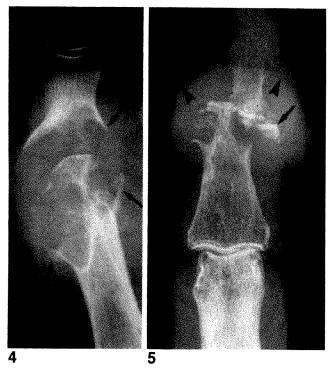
Radiograph shows well-defined erosions on both sides of joint and "overhanging margins" (arrows) in patient with gout.
